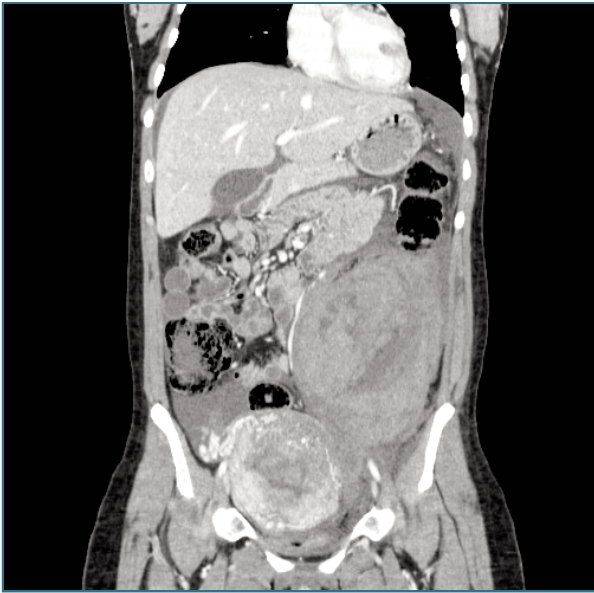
Abdominal-pelvic CT scan performed 2 days postpartum, showing a retroperitoneal hematoma measuring at least 12 × 13.4 × 19 cm (anteroposterior × transverse × longitudinal), localized in the left flank and iliac fossa. An enlarged uterus with a heterogeneous enhancement pattern results from normal postpartum changes.
